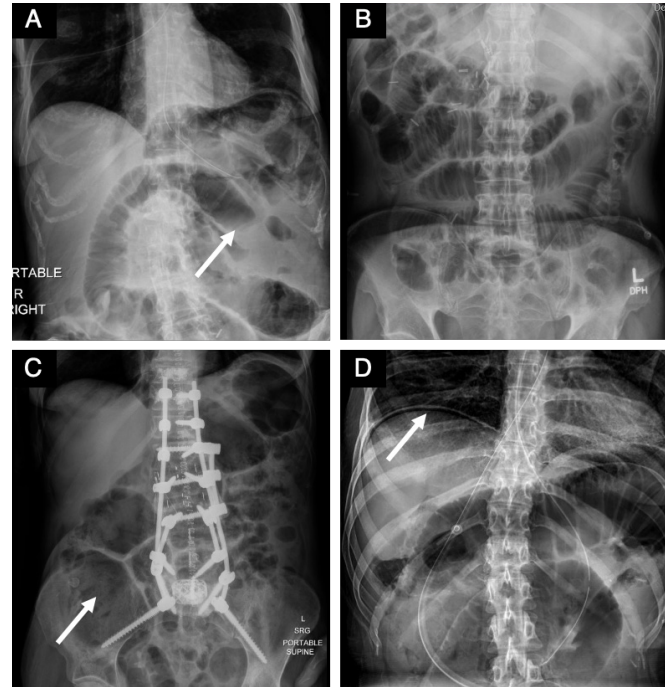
The abdominal radiograph is an important tool in the diagnosis of SBO
